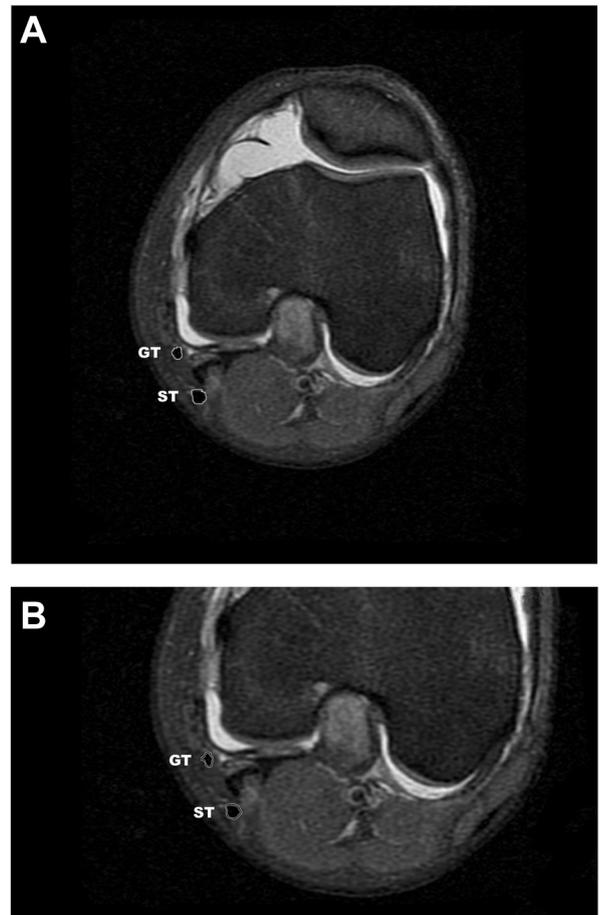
Axial fast spin echo T2-weighted sequence with fat saturation of a left knee. (A) Under 2× magnification, the semitendinosus tendon (ST) and gracilis tendon (GT) had a cross-sectional area (CSA) of 28.05 mm². (B) In the same view but under 4× magnification and following the method described by Hamada et al,⁸ the CSA of the ST and GT was 19.21 mm². With this method, the CSA inside the inner circle (16.15 mm²) was added to 50% of the CSA of the area between the outer and the inner circle, which had a CSA of 6.12 mm².
